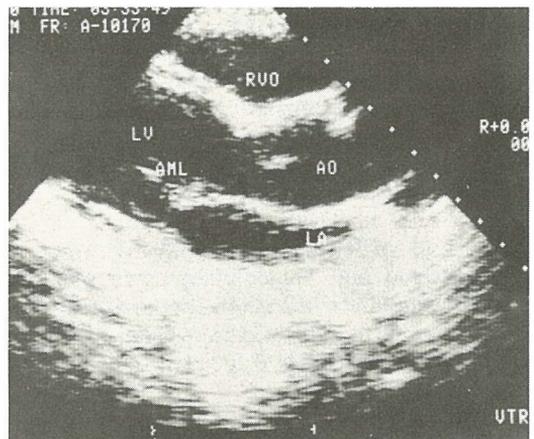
Two-dimensional echocardiogram of aortic root aneurysm the same patient as in fig. 3. RVO = right ventricular outflow tract, AO = aorta, LA = left atrium, LV = left ventricle, AML = anterior leaflet of mitral valve
